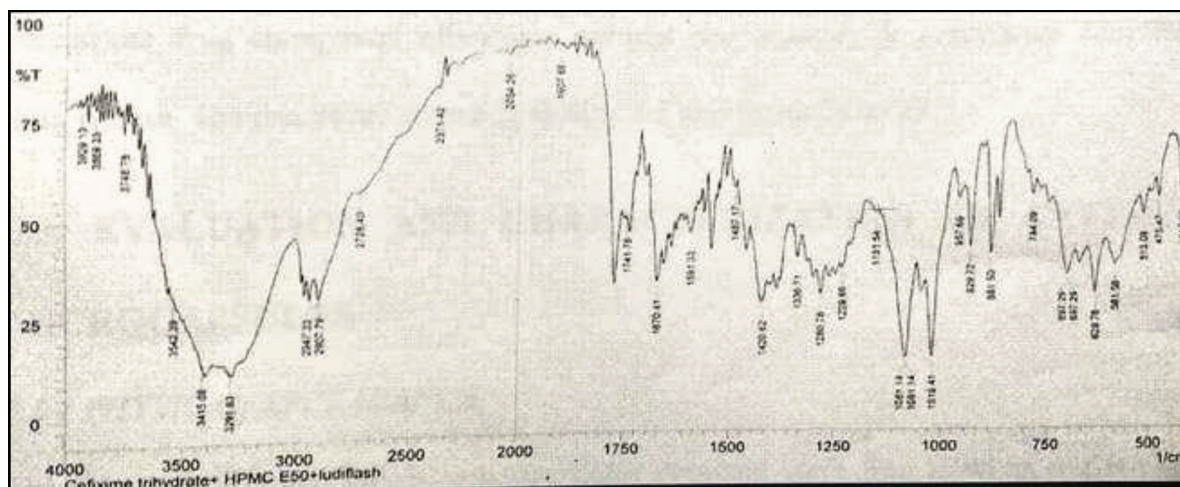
FTIR of FF11 ODMTs (CT + optimised hydroxypropyl methylcellulose E50 microcapsules + ludiflash)
